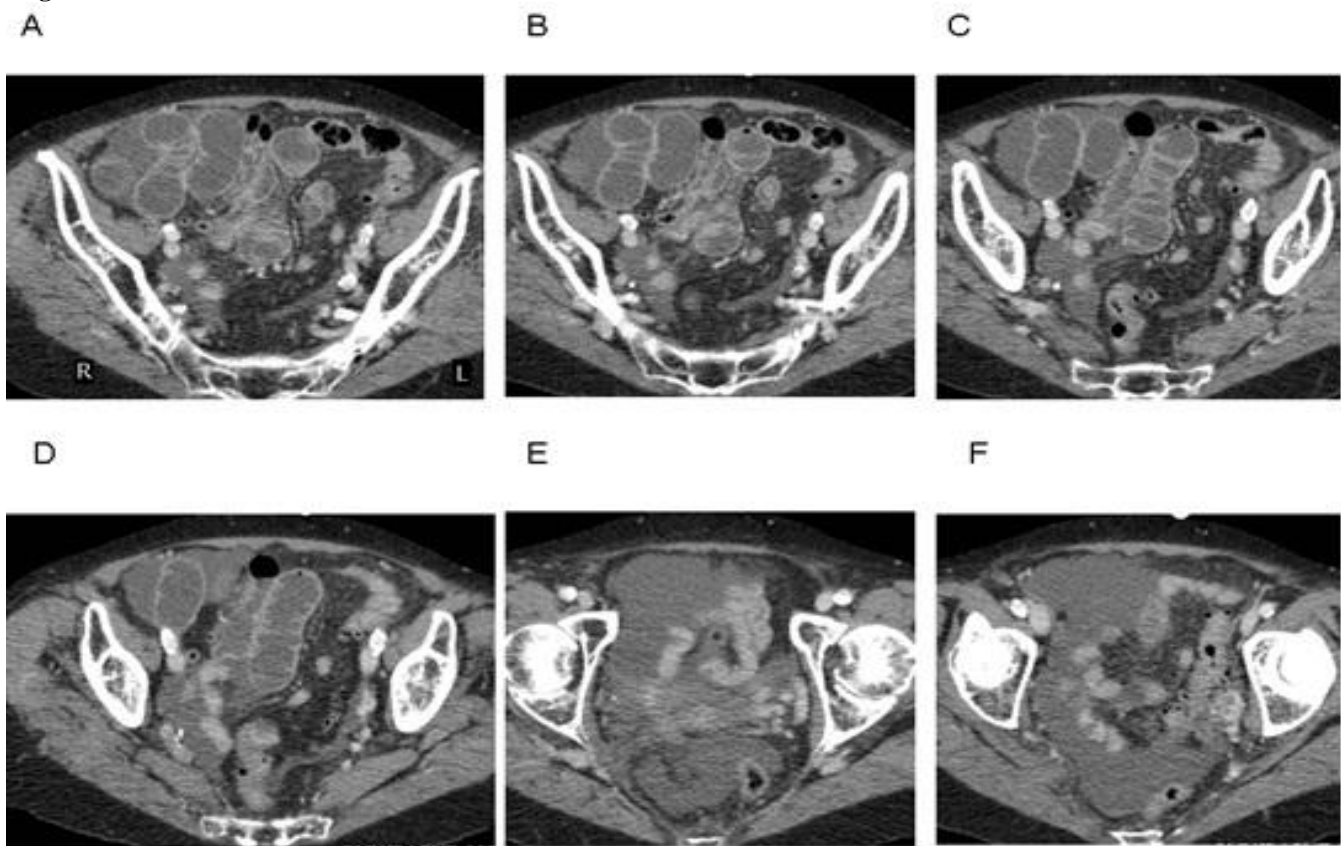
CT Scan of pelvis- note the collapsed small bowel loops with trickle of contrast and no gas in the rectum and large bowel
